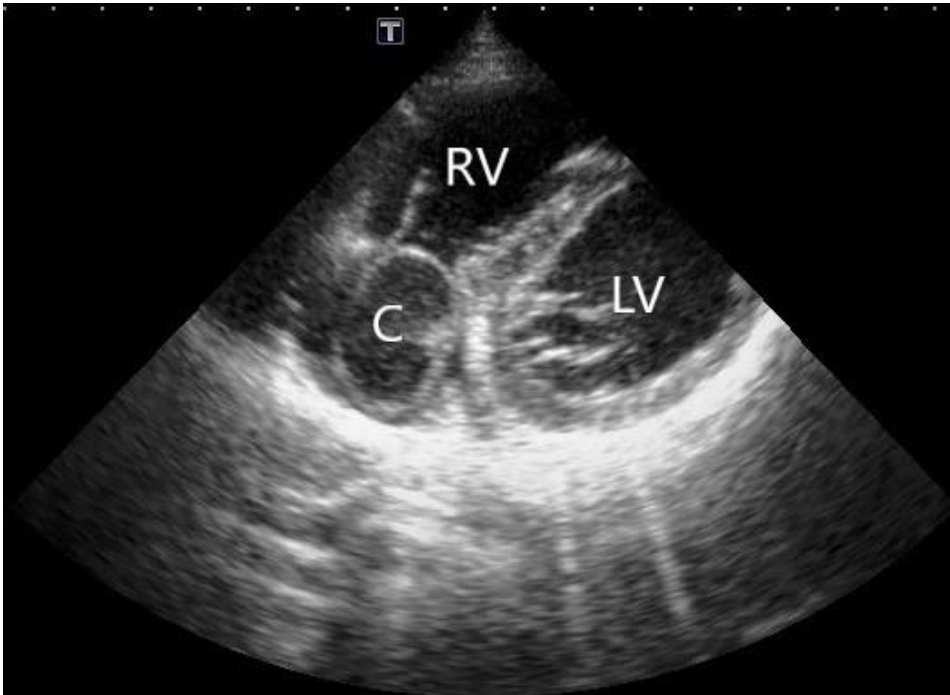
Echocardiographic image. The modified apical right ventricular inflow view
